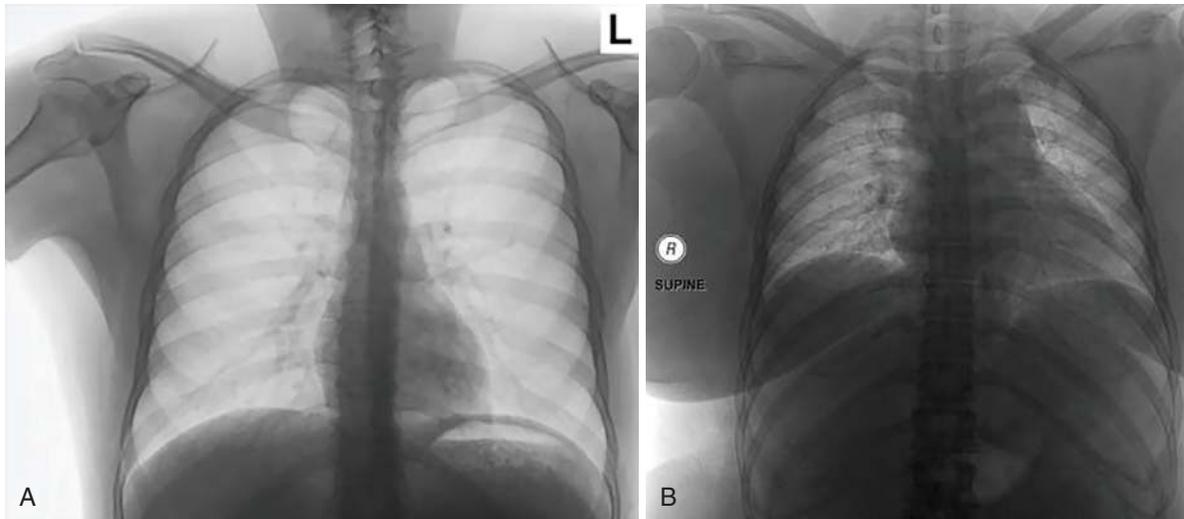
A, Normal posteroanterior (PA) upright chest radiograph. Note the definition and dimensions of the heart and vascular structures. B, Supine anteroposterior (AP) chest radiograph in massively obese normal subject. Note the widened mediastinum, enlarged heart shadow, and symmetrically elevated hemidiaphragms.
